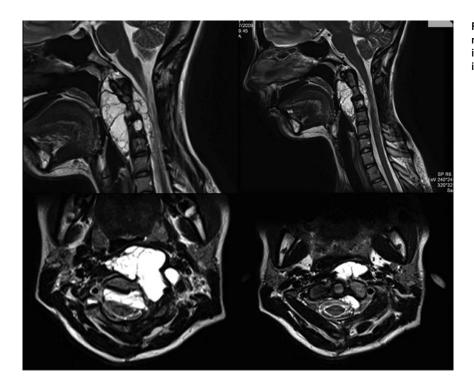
Sagittal and axial T2-weighted magnetic resonance imaging showed diffuse increased signal of a lesion of C2-C3-C4 with important retropharyngeal portion.
